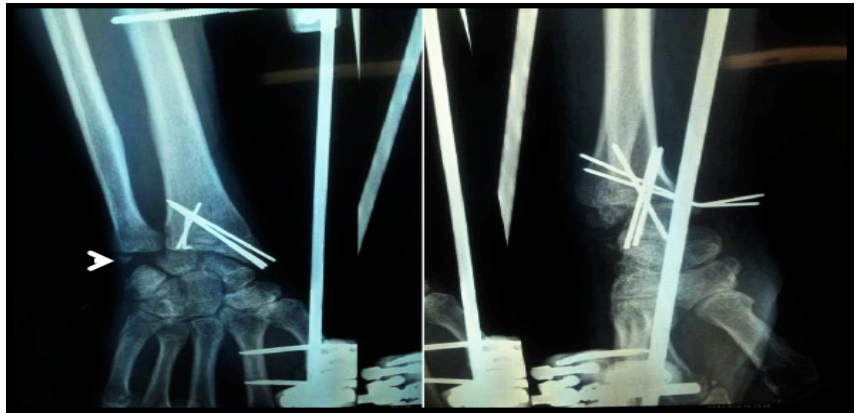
Postoperative radiography showing reduction and fixation of articular fragment with Kirschner wires and neutralization with external fixation. We noted a displacement of the fracture of the tip ulnar process (white arrow). In all of our cases we have used an antero-medial approach which allows direct access to the fragment of the lunate facet and easier visualization of the distal radio-ulnar joint compared to the Henry approach.
